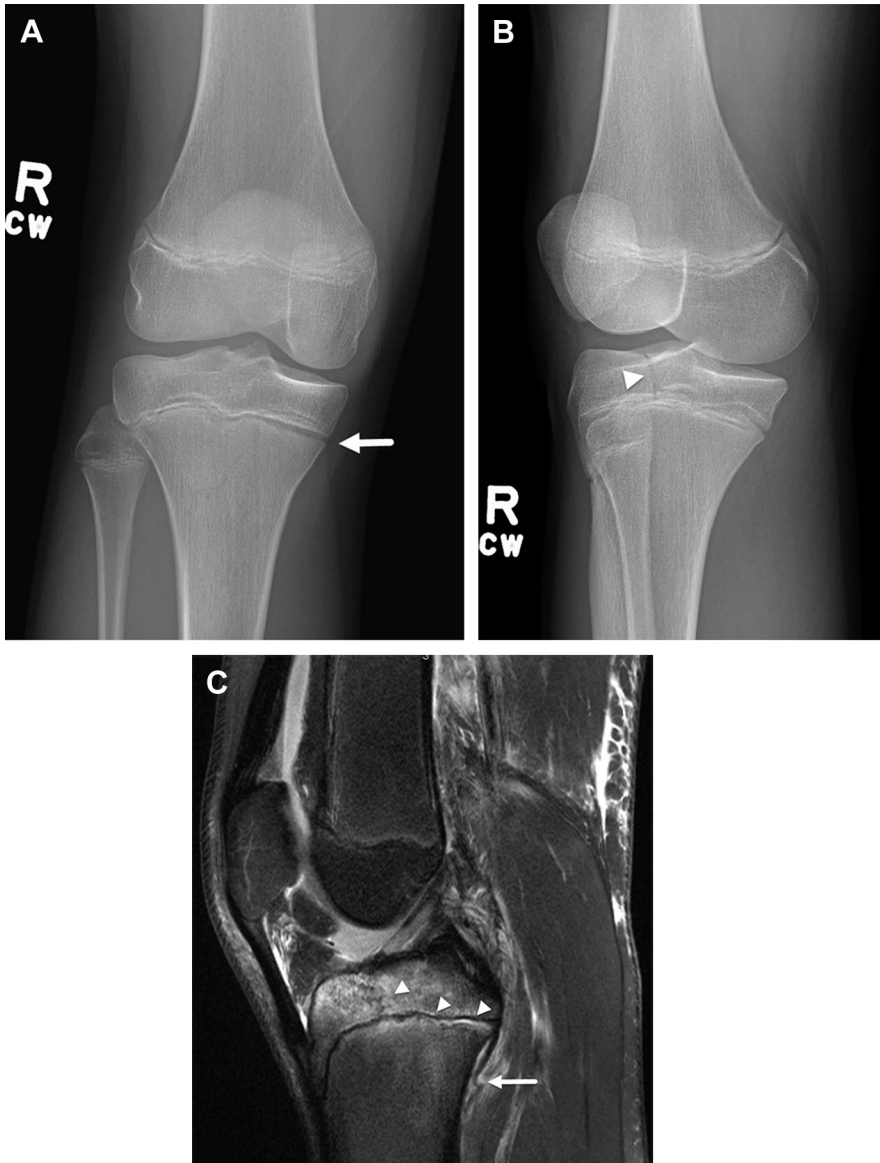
Salter-Harris type III fracture of the right proximal tibia in a 15-year-old boy after soccer tackle. (A) Frontal and (B) oblique radiographs demonstrate widening of the medial physis (*arrow*) with epiphyseal lucent fracture line (*arrowhead*). (C) Sagittal intermediate-weighted fat-saturated MR image confirming nondisplaced fracture line (*arrowheads*) extending from the posterior physis into the epiphysis. There is disruption and superior retraction of the posterior tibial periosteum (*arrow*).
